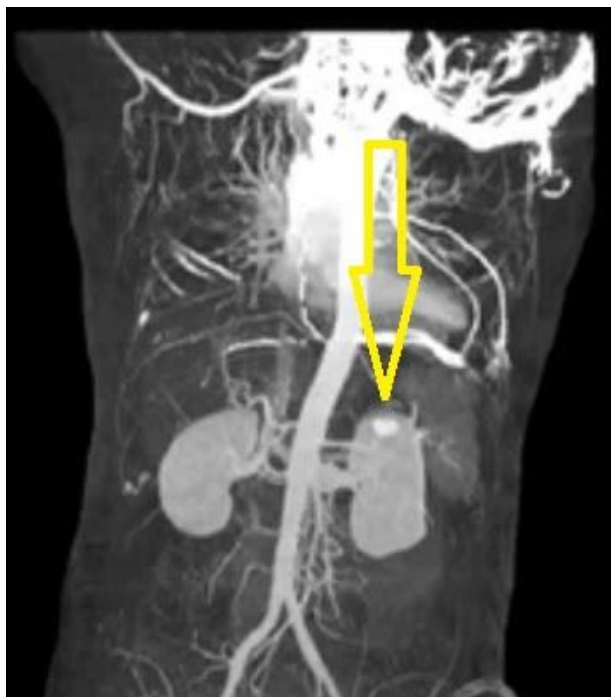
Computed tomography (CECT) of the abdomen showing ruptured splenic artery aneurysm (yellow arrow)
